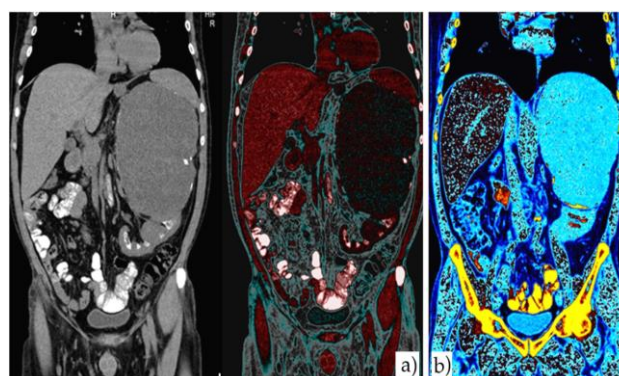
Different color-coded coronal sections of native CT scan showing large retroperitoneal mass with an axial diameter of about 182/136 mm and a craniocaudal diameter of approximately 212 mm.
